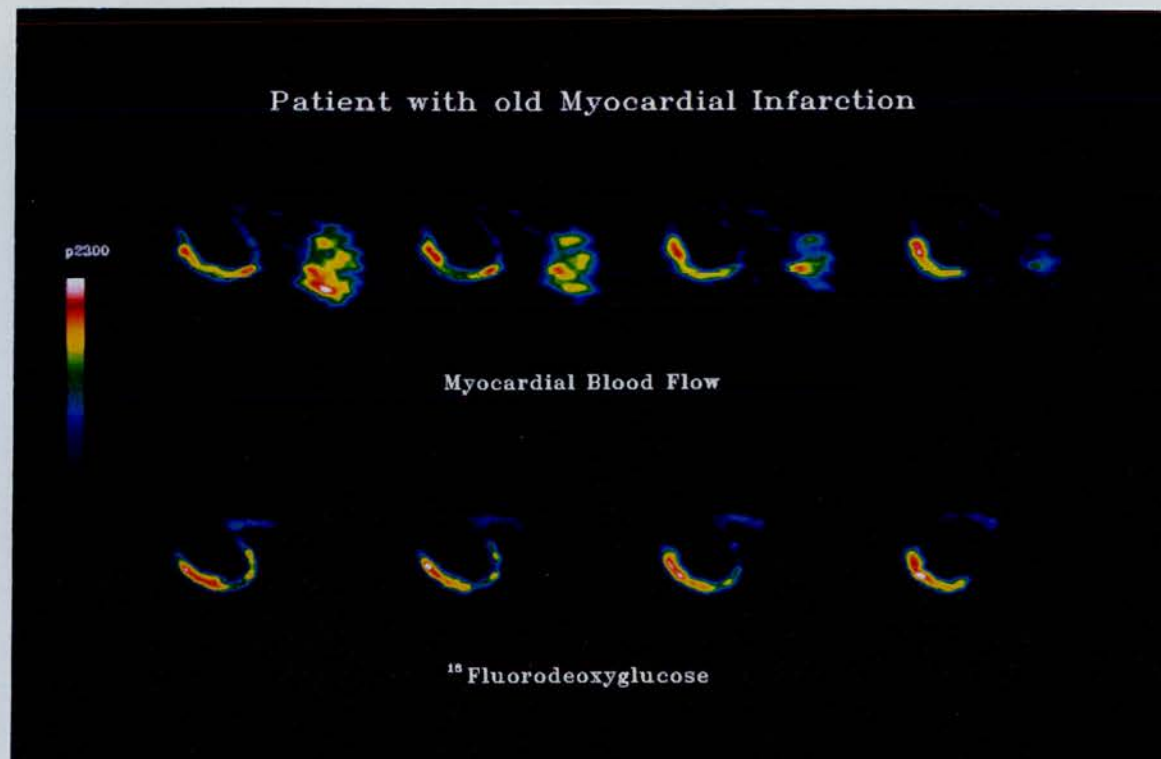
Upper panel) MBF washout and FDG images over four adjacent myocardial planes in a patient with a previous extensive anteroapical myocardial infarction. MBF and FDG uptake is extremely low in the septal, anterior and apical regions, but equally preserved in the lateral and inferoposterior regions - "flow-metabolism match". Lower panel) MBF washout and FDG images in two myocardial planes in another patient with a previous anteroapical myocardial infarction. MBF is low in the anterior and septal regions but FDG uptake is preserved in all myocardial regions "flow-metabolism mismatch".
